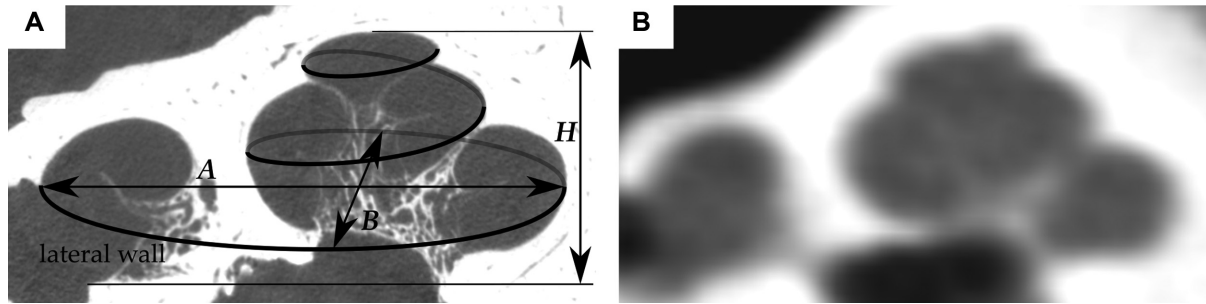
Cross-sectional image of the same cochlea derived from (A) micro-computed tomography and (B) cone beam computed tomography data. The former image also shows a visualization of the cochlear lateral wall and the global cochlear dimensions A , B , and H .
